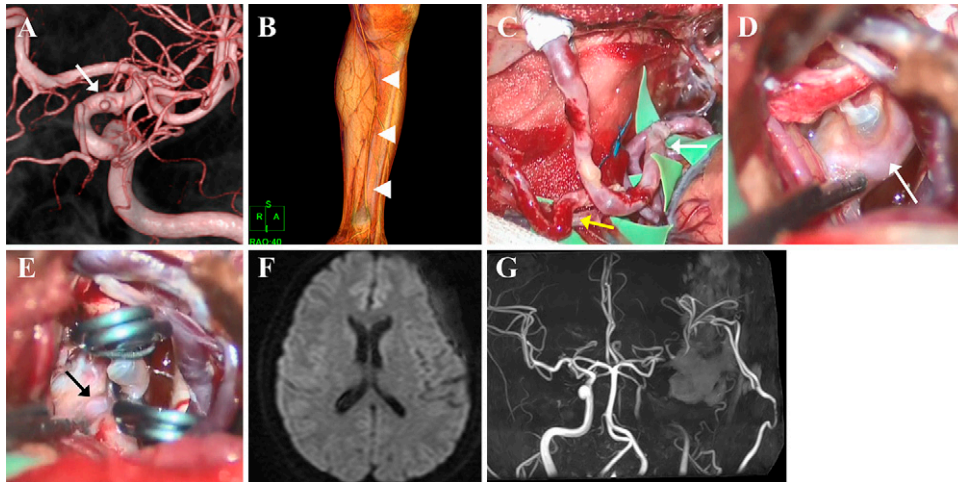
A: 3D CT angiography revealed an aneurysm on the anterior wall of the left ICA (*arrow*). B: Non-enhanced 3D CT venography demonstrating a saphenous vein for the bypass graft (*arrowheads*). C: The STA-M4 bypass (*yellow arrow*) and the ECA-saphenous vein-M2 bypass (*white arrow*) were established. D: Intraoperative view showing a BBA (*white arrow*) in the left ICA. E: The aneurysm was trapped while preserving the origin of the PCOM artery (*black arrow*). F: Postoperative diffusion-weighted MRI showed no cerebral infarction. G: MRA demonstrated that the SVG was occluded, resulting in the STA-MCA assist bypass becoming dominant.
